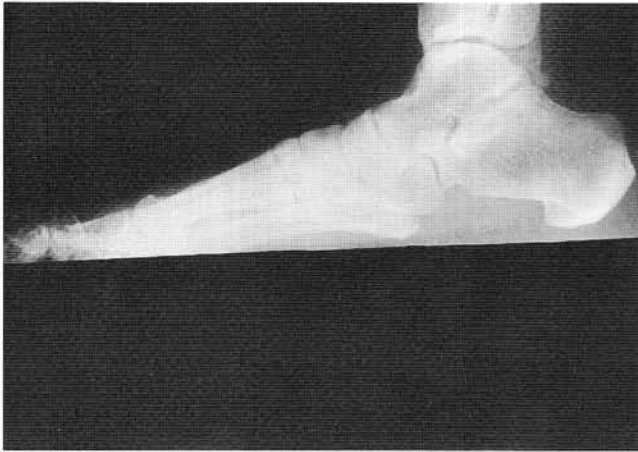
Preoperative lateral radiograph.
